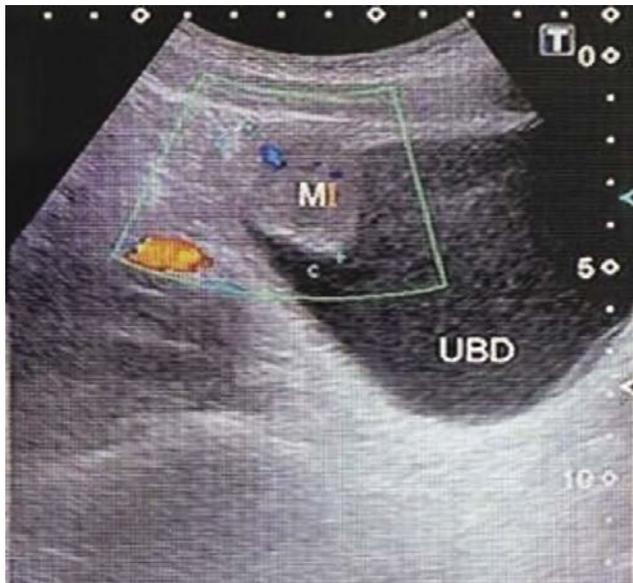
Ultrasound showed presence of urinary bladder mass
